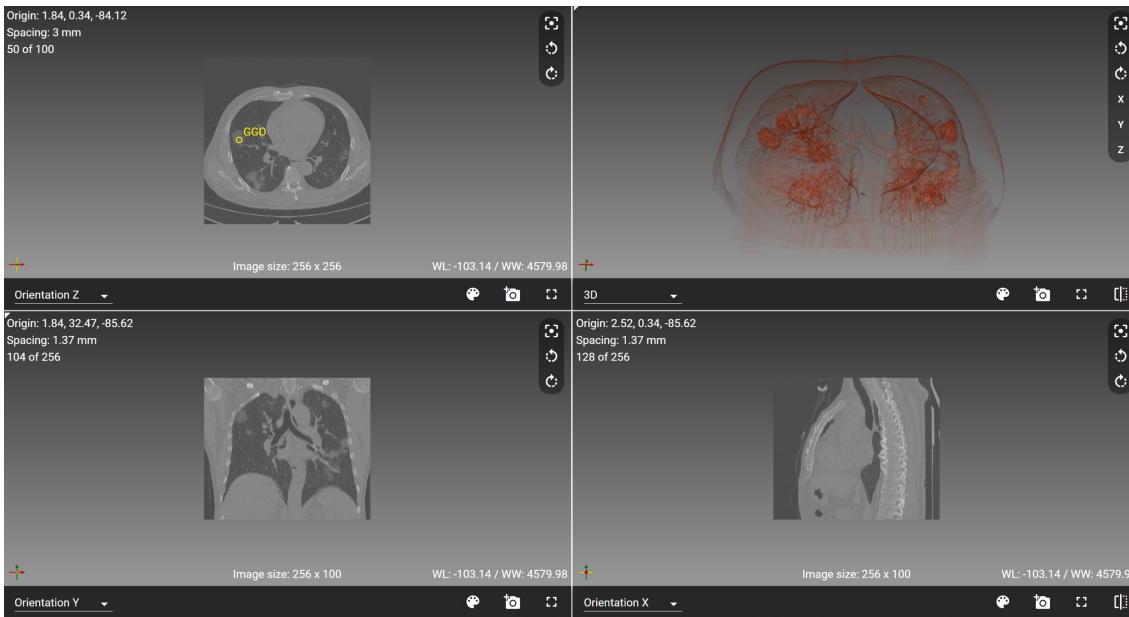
Sample COVID patient 2D and 3D rendering using Paraview Glance and its built-in CT-Lung transfer function
